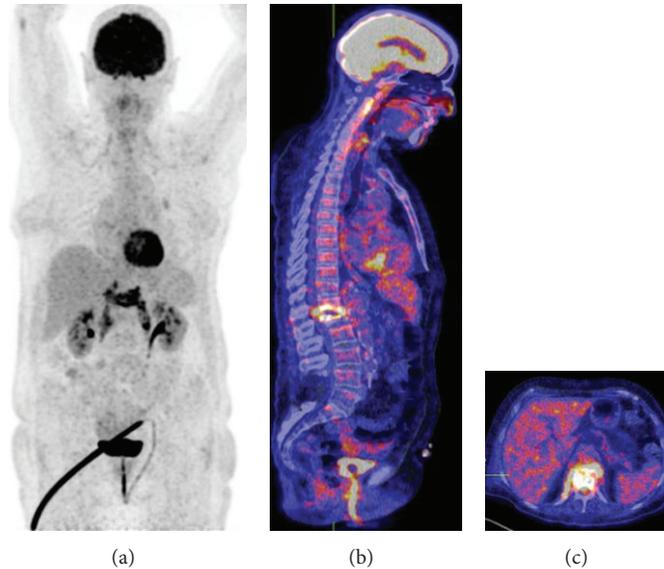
FDG-PET of a patient with spondylodiscitis and involvement of the psoas muscles. (a) Coronal MIP view, (b) fused PET/CT sagittal view, and (c) fused PET/CT transaxial view.
